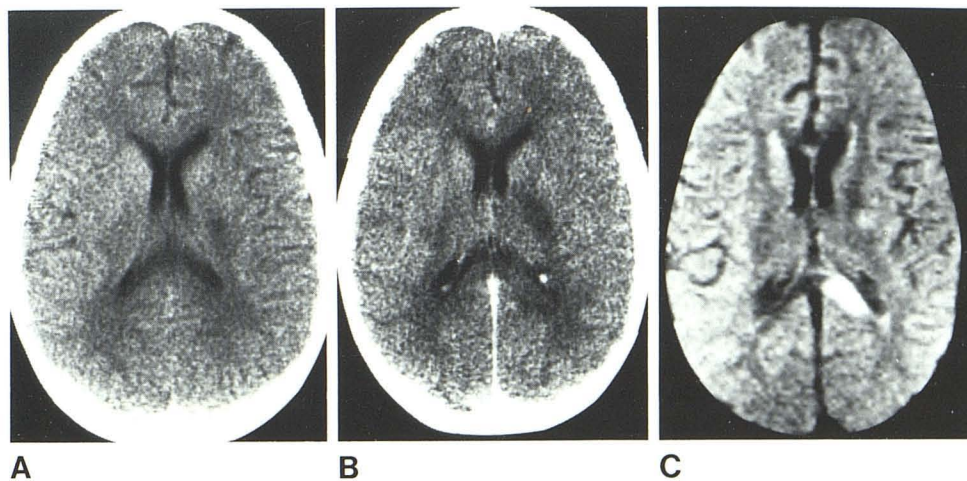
Postinfectious encephalitis. CT before (A) and after (B) intravenous contrast shows nonenhancing low-density lesion in left internal capsule. C, SE NMR image at comparable level depicts high-intensity focus not only in left internal capsule but also one in left major (posterior) forceps of corpus callosum.
